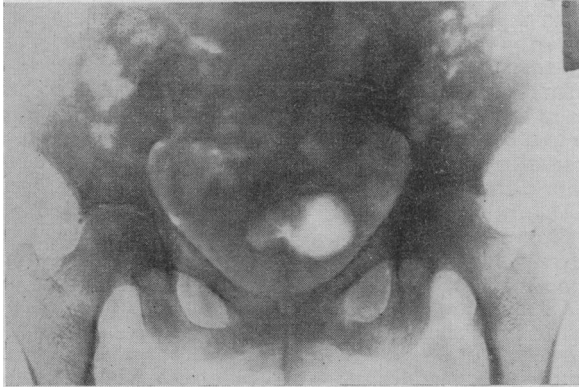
Radiograph of the pelvis, showing stress fractures in the pubic rami of a patient suffering from chronic renal failure. The fractures healed with subsequent treatment.
